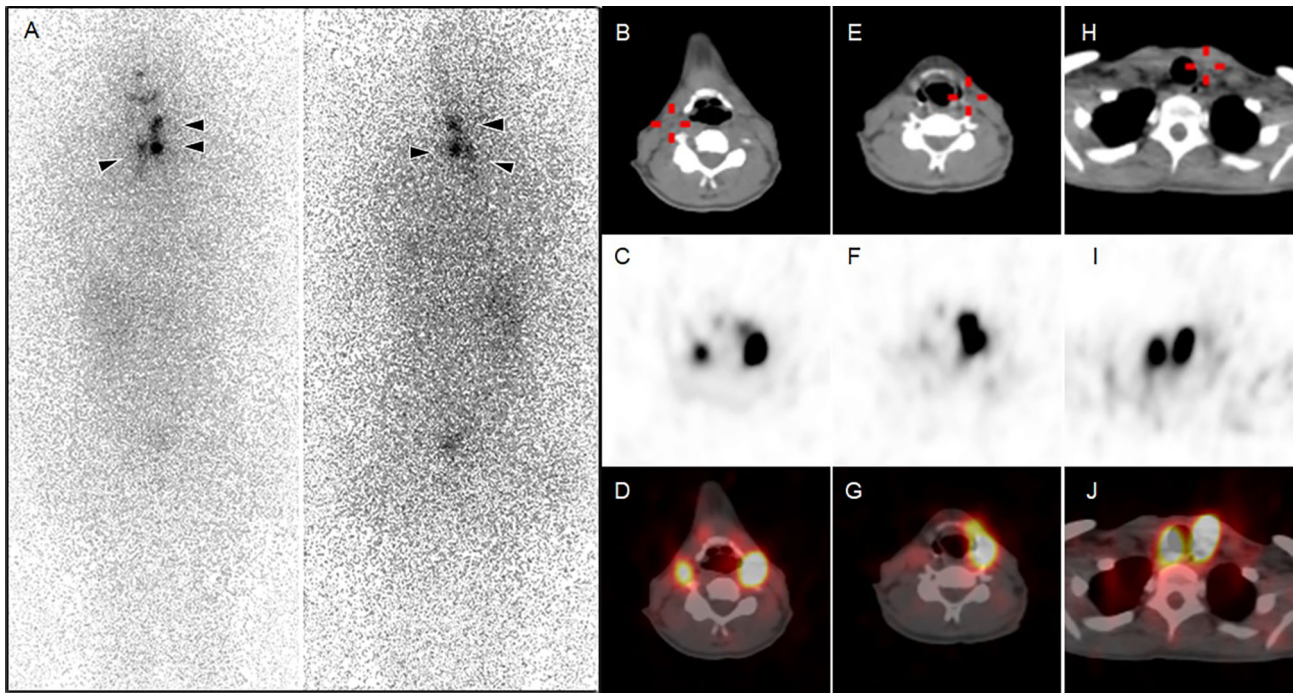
Imaging after initial I-131 treatment. a RAI-WBS with accumulation in the thyroid remnant and neck lymph nodes. b, e CT, c, f single-photon emission computed tomography (SPECT), and d, g transaxial fused SPECT/CT identified bilateral upper and middle cervical lymph nodes with uptake of the radiopharmaceutical. h CT, i SPECT and j transaxial fused SPECT/CT identified left thyroid remnant and right upper paratracheal nodal uptake of the radiopharmaceutical
